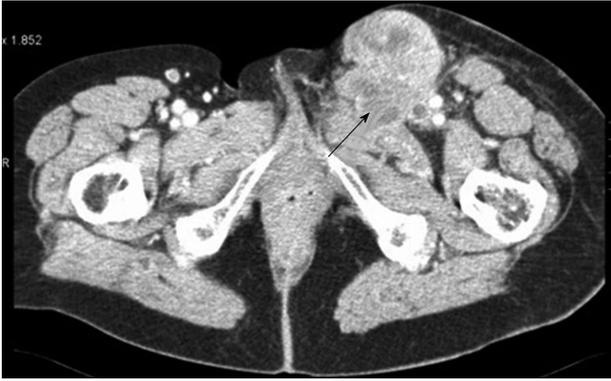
Axial cut computed tomography angiogram demonstrating proximity of a soft tissue sarcoma to the adjacent femoral vessels (arrow).
